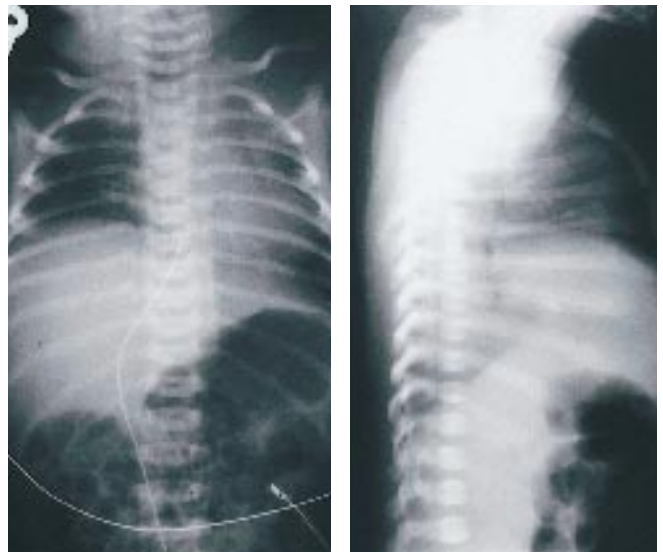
Anteroposterior and lateral radiograph of the chest in an infant with a right Erb's palsy. Note the ipsilateral paralysis of the right diaphragm due to phrenic nerve palsy which may occur in association with upper motor brachial plexus trauma. A rare complication associated with Erb's palsy is a Horner's syndrome on the same side, due to involvement of the cervical sympathetic nerves. If Horner's syndrome persists, the infant may develop heterochromia iridis caused by failure of development of secondary pigmentation in the affected eye.
